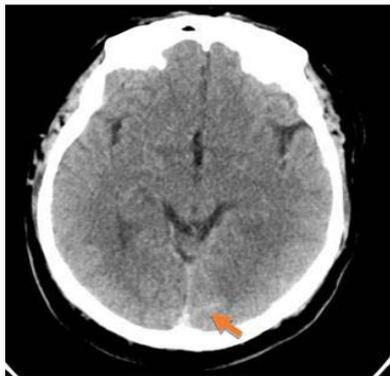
Non contrast brain computed tomography. Axial cut showing a left occipital sulcal linear hyperdensity (red arrow).
